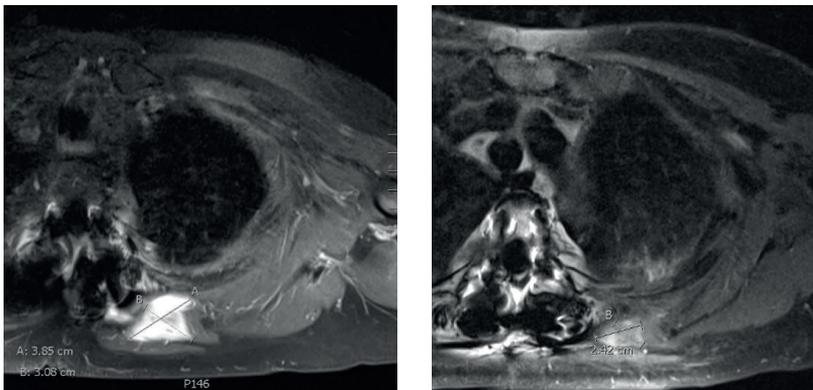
Desmoid tumor growing in the upper back adjacent to the region previously operated because of osteoporosis. Concurrent unspecified findings in the lungs and thyroid gland proved to be a metastatic follicular thyroid carcinoma. The desmoid causing pain and discomfort was treated with 60 Gy in 2 Gy fractions radiotherapy. Six months after radiotherapy magnetic resonance imaging (MRI) displayed decreased T2 signal intensity and stable disease.
